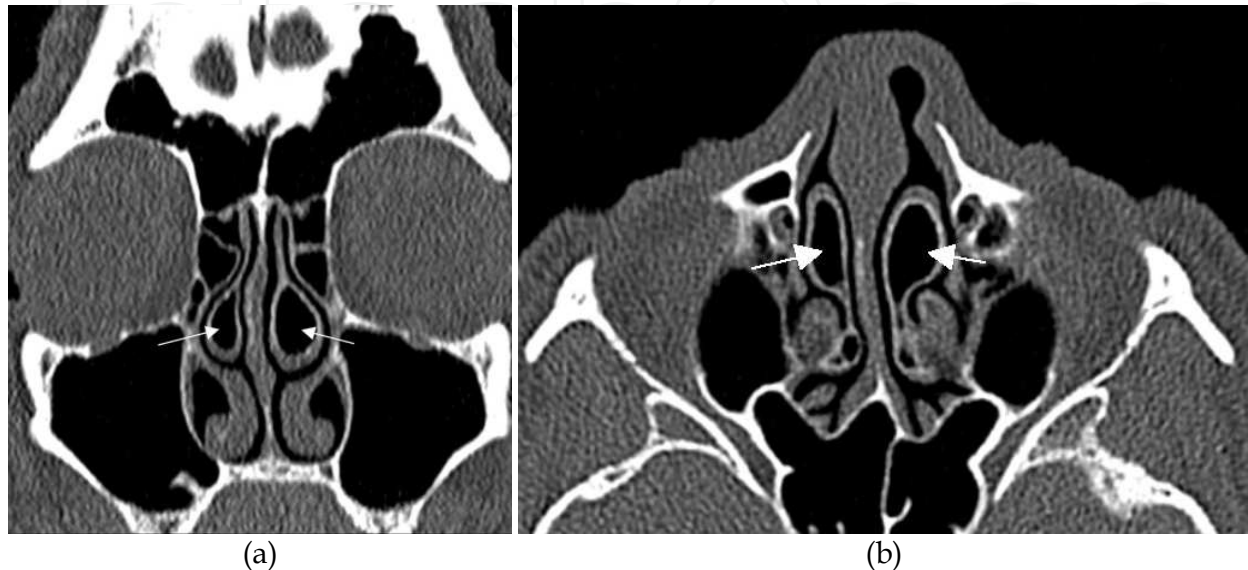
CT is the primary modality in sinonasal imaging. (a) Coronal CT through the anterior paranasal sinuses with the maxillary, anterior ethmoid including bilateral concha bullosa (arrows) and the frontal sinuses. (b) Axial CT through sphenoid, maxillary and ethmoid sinuses with bilateral concha bullosa (arrows).
